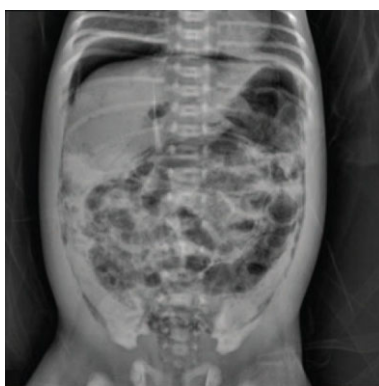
x-ray of an Infant with NEC This photo shows an abdominal film with pneumatosis intestinalis, a radiologic sign seen in patients with necrotizing enterocolitis (NEC). The abdominal x-ray shows the intramural air bubbles that occur in the bowel wall from gas produced by bacteria in the intestinal wall lining. Note the bubbly lucencies filling the abdominal cavity. (credit: "Pneumoperitoneum and Pneumatosis Intestinalis" by Sheng Q, Lv Z, Xu W, Liu J, Wu Y, Shi J, Xi Z. /Wolters Kluwer Health, CC BY 4.0)
